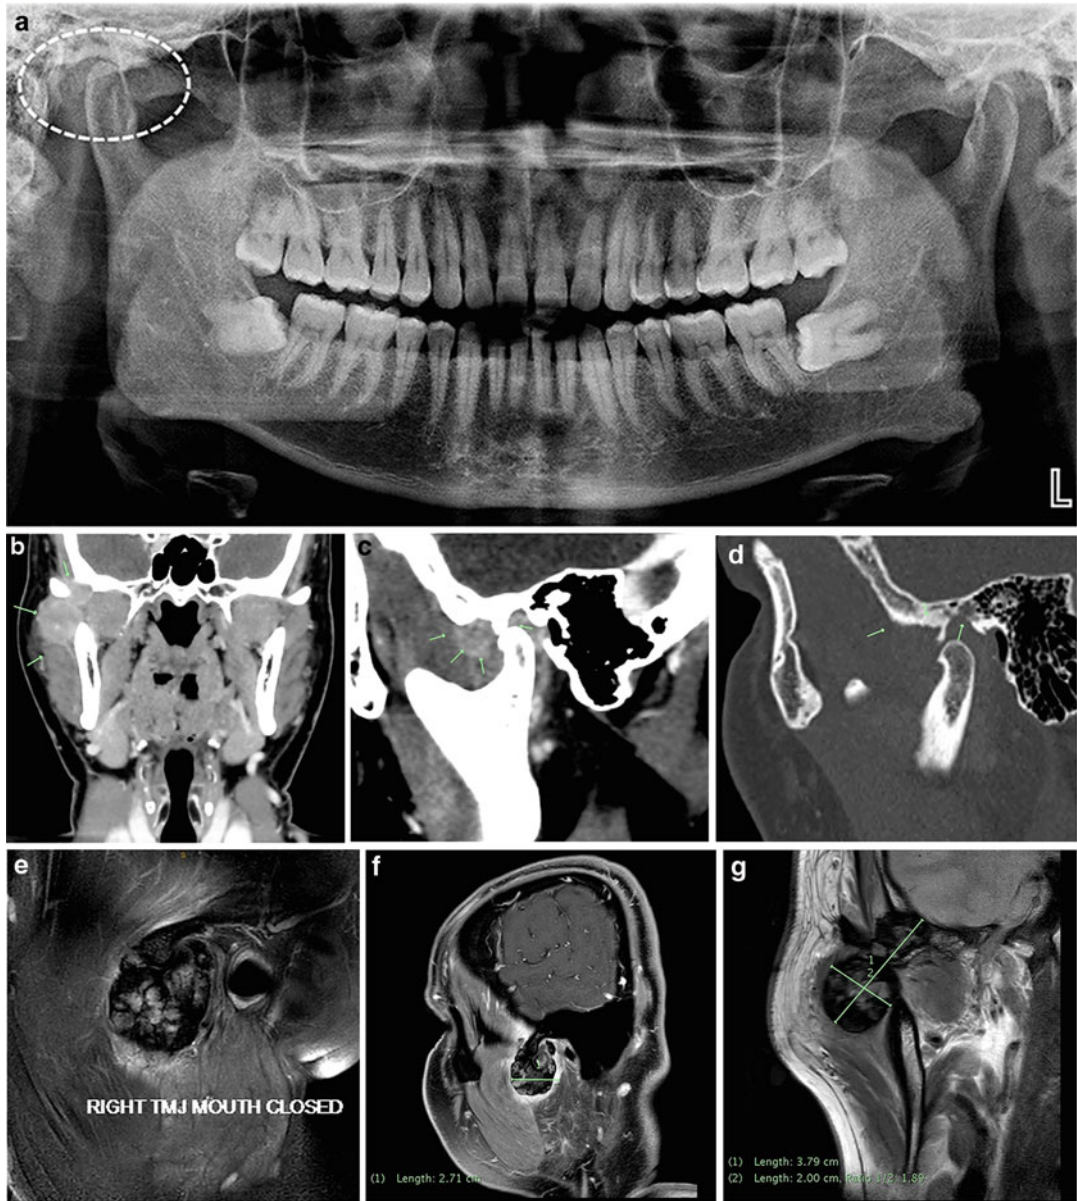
Pigmented villonodular synovitis. Orthopantomogram (a) showing circumscribed lucency overlying the right articular eminence (white dotted oval). No temporomandibular joint arthropathy or other osseous abnormalities are seen. On CT (b–d) there is an avidly enhancing 27 × 24 × 27 mm right preauricular mass lesion which appears to be centered within the posterior aspect of the masseter muscle (b) and extends anterosuperiorly to involve the posterior aspect of both the medial and lateral pterygoid muscles (b + c). This component scallops the greater wing of the sphenoid bone (d) and the anterior aspect of the articular eminence of the right temporomandibular joint. There is only a tiny component
